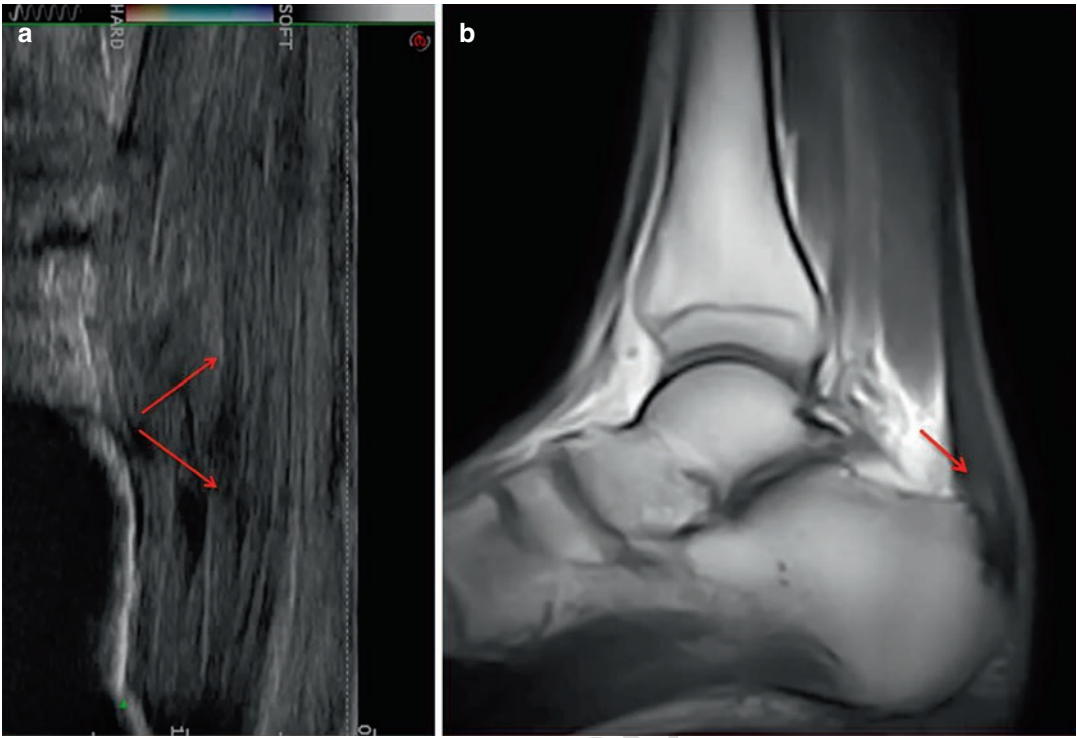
(a, b) Dynamic US and MRI scans documenting transmural rupture of the Achilles tendon
